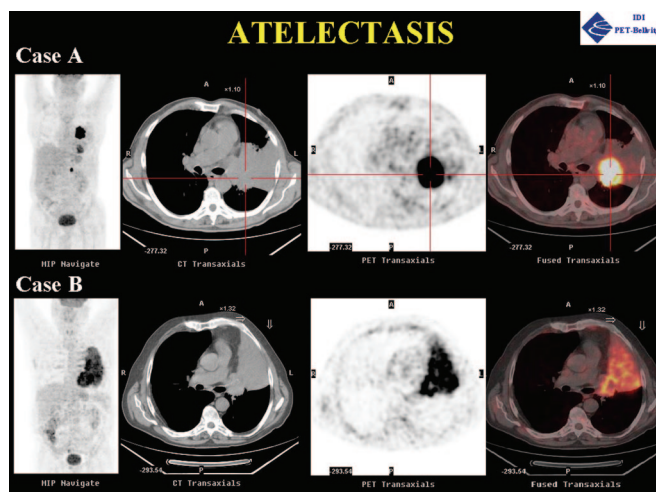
Representative positron emission tomography/computed tomography images from two patients with lung cancer associated with atelectasis in which computed tomography cannot delineate the exact localization of the tumor. (A) A 60-year-old man with left lung adenocarcinoma limited to the perihilar region causing distal normometabolic atelectasis. Unsuspected left adrenal hypermetabolic lesion is observed consistent with metastases. (B) A 67-year-old man with squamous cell carcinoma in the upper lobe of left lung where tumor has replaced the lobe showing extensive hypermetabolism (replacement atelectasis).
